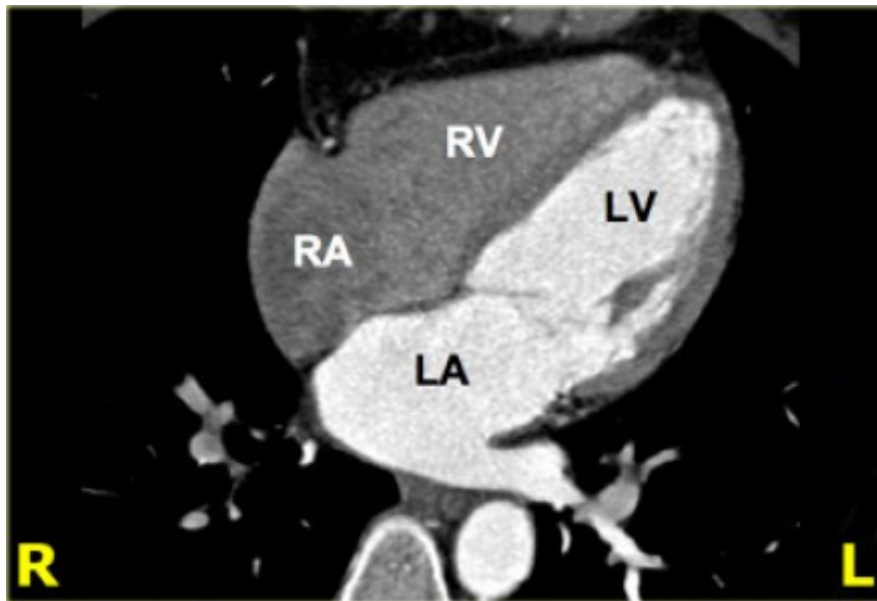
CT 4chamber view showing RA=right atrium, RV=right ventricle, LA=left atrium, LV=left ventricle (*Ho et al., 2006*).
